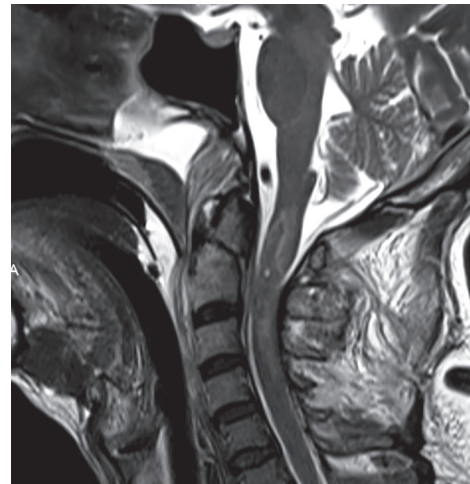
Magnetic resonance imaging sagittal view showing type II odontoid fracture and cervical cord contusion at that level
